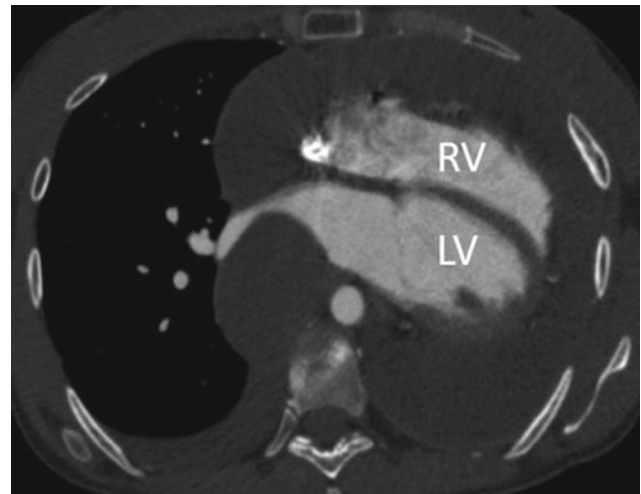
CT contrast angiography after 8 months of pazopanib treatment demonstrating dramatic reduction in right ventricular size but the left ventricle is somewhat dilated and globular
